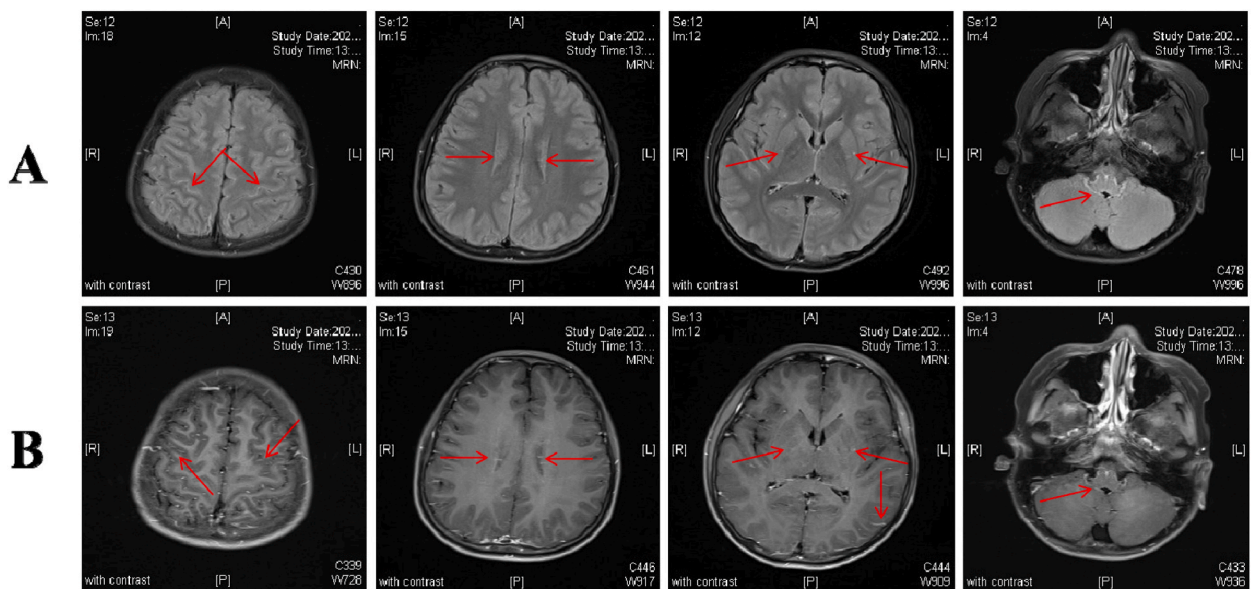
Representative image of cranial MRI. (A) MRI images of the brain on the 11th day of onset.
